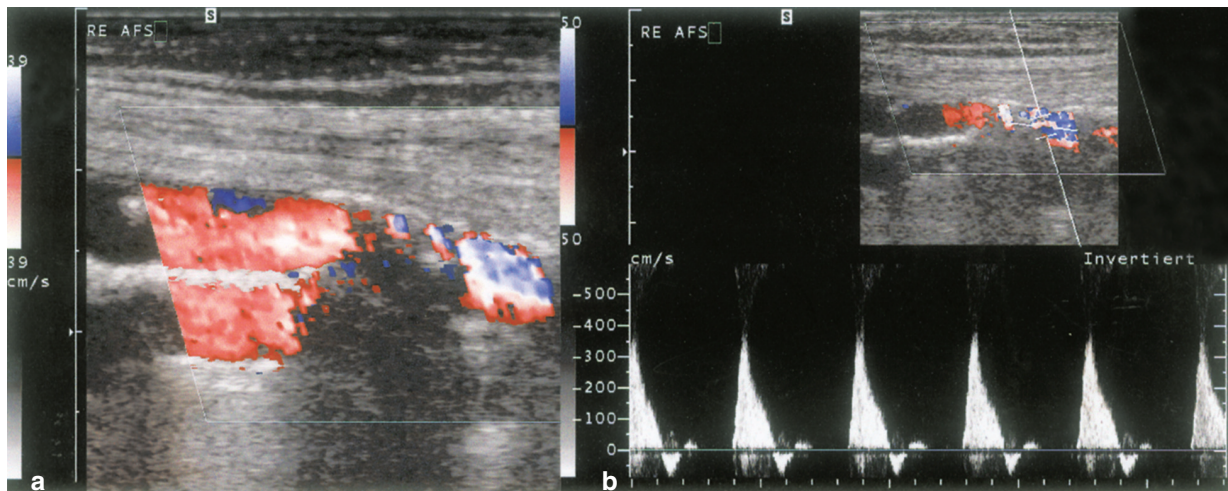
High-grade stenosis of the superficial femoral artery. a) Narrowing of the lumen is seen in color Doppler mode as well as color aliasing and turbulence. b) An increase of the peak systolic velocity to 350 cm/s representing a high-grade stenosis is shown in triplex mode.
